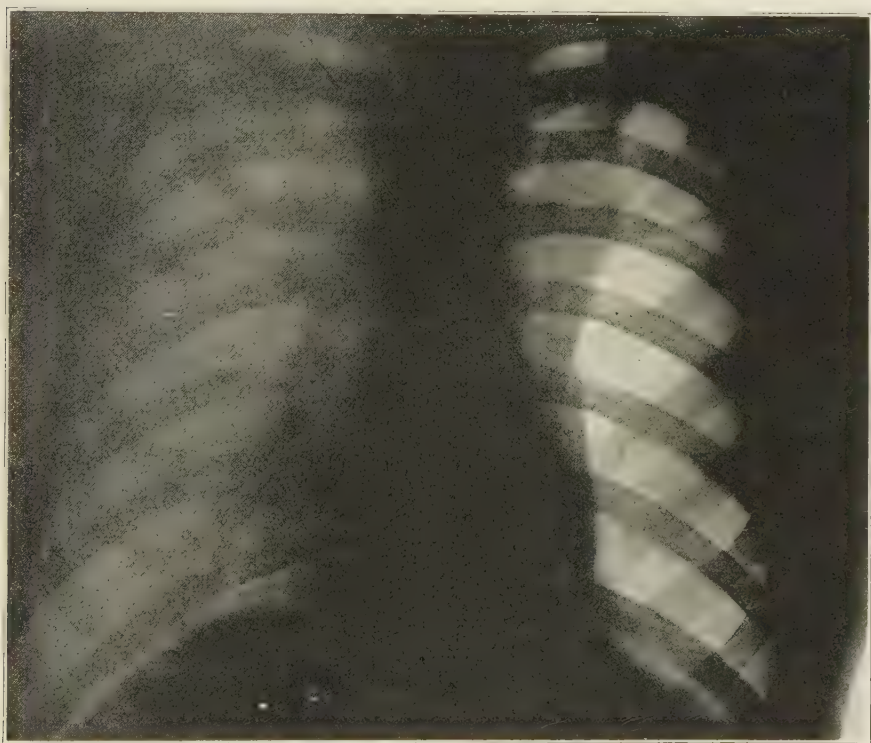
Case II. Radiograph of chest after production of pneumothorax on one side. December, 1921.
